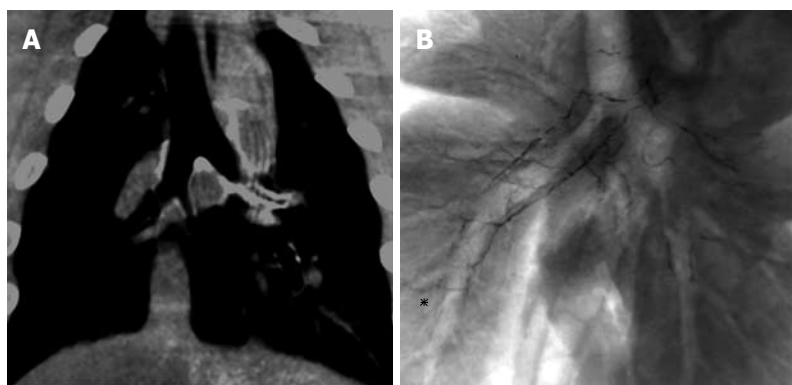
Embolization of right bronchial artery with n-butyl cyanoacrylate lipiodol was conducted. Two days after bronchial artery embolization (BAE) of bilateral bronchial arteries, chest computed tomography showed accumulation of n-butyl cyanoacrylate lipiodol (NBCA-Lp) alongside the bronchial trees (A). Chest radiography of the sacrificed lung two days after BAE with NBCA-Lp showed accumulation of NBCA-Lp that corresponded to the bilateral branch arteries of the main bronchus, lobar bronchus, and segmental (asterisk) bronchi (B).
